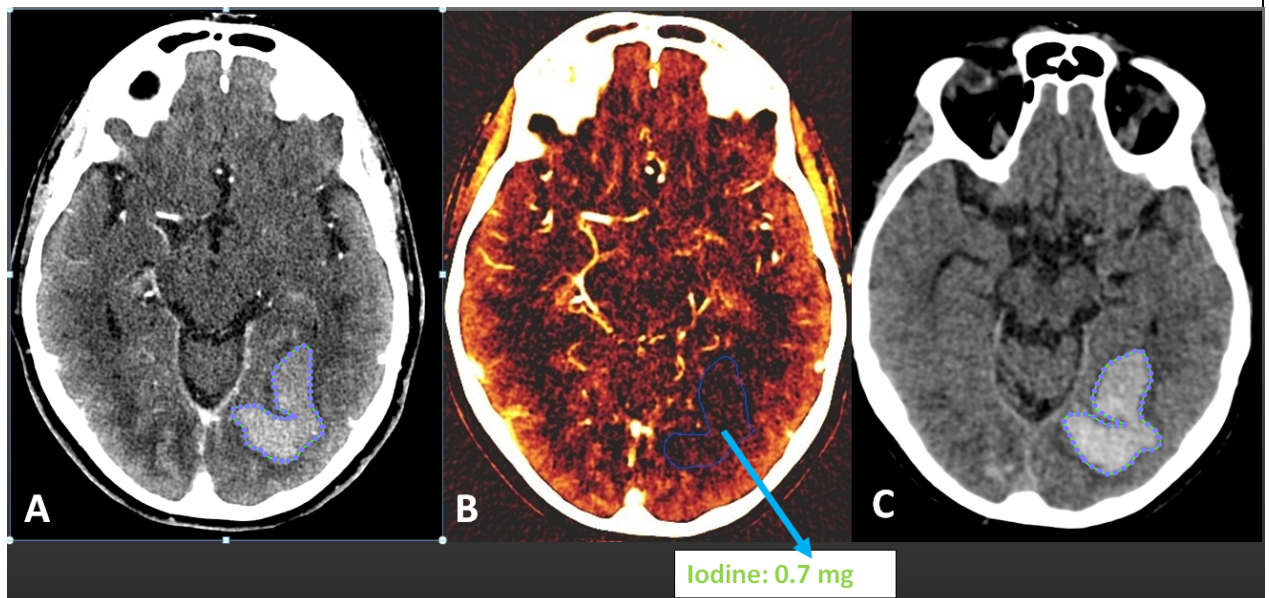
Minimum iodine concentration (0.7 mg) on delayed DECT images (B) and no hematoma expansion on subsequent CT exam (C)
